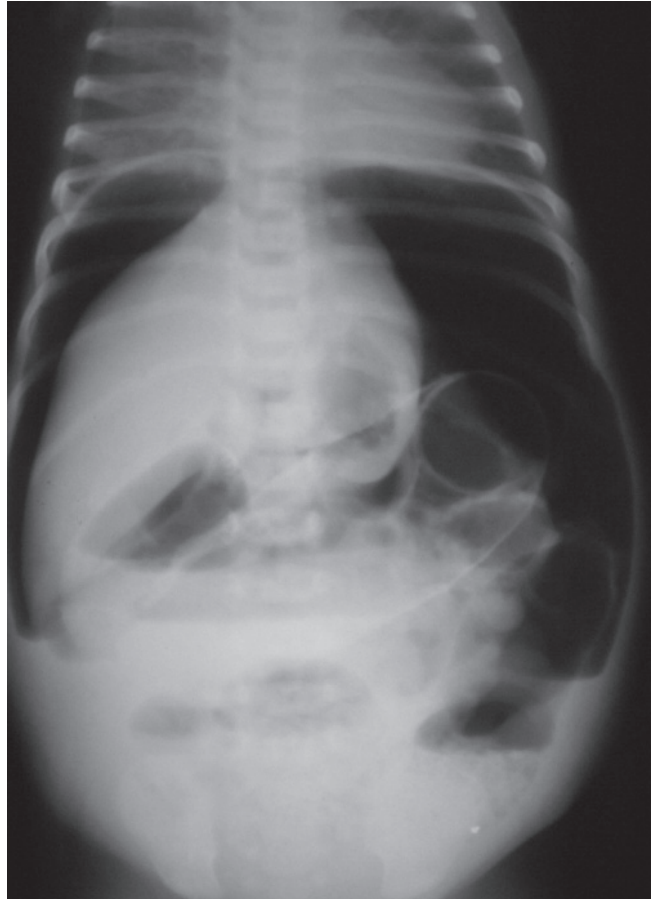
A plane radiograph of the newborn reveals intra-abdominal free air and multiple air-fluid levels.
